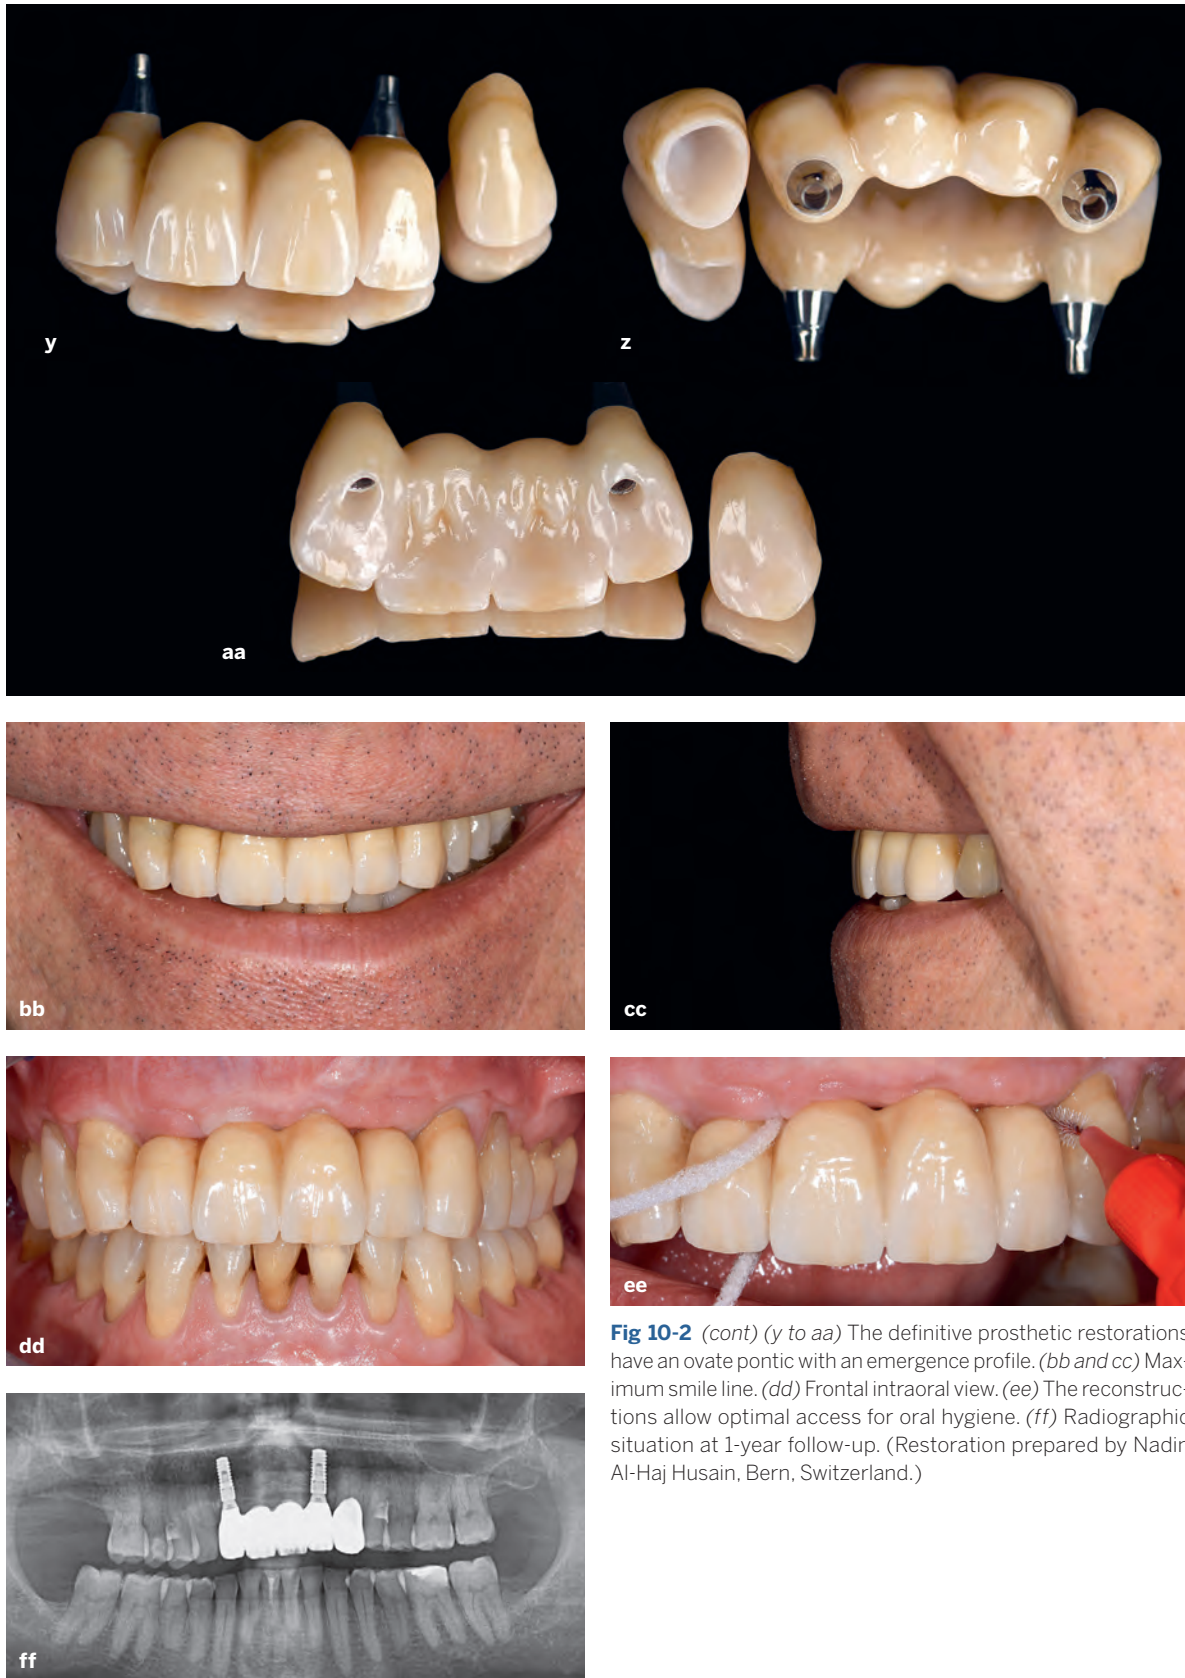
(cont) (y to aa) The definitive prosthetic restorations have an ovate pontic with an emergence profile. (bb and cc) Maximum smile line. (dd) Frontal intraoral view. (ee) The reconstructions allow optimal access for oral hygiene. (ff) Radiographic situation at 1-year follow-up. (Restoration prepared by Nadin Al-Haj Husain, Bern, Switzerland.)
